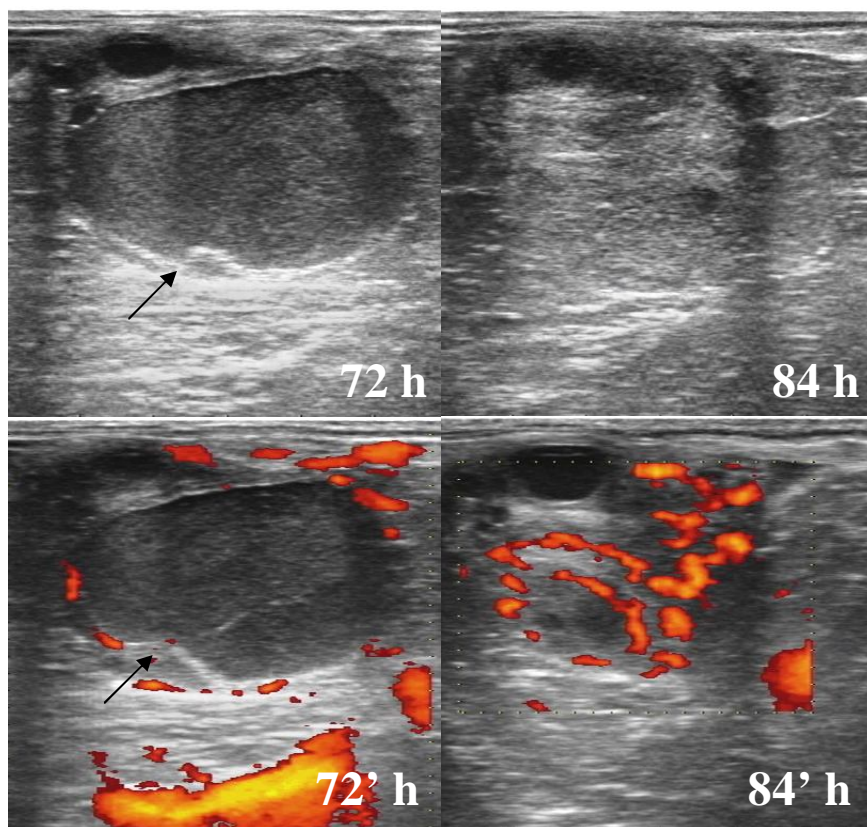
B-Mode and Colour-Doppler sonograms of a mare from LUF CLO 33 group. The mare was treated with 1.7 mg/kg flunixin-meglumine i.v. every 12 h from 0 to 36 h after hCG (0 h) and 250 μ g cloprostenol i.v. at 33, 35 and 36 h after hCG. The luteinized unruptured follicle (LUF) showed signs of follicular haemorrhage by 48 h. The LUF contents score increased gradually thereafter until 72 h. Between 72 and 84 h, the LUF collapsed. Note the disruption in the follicular wall integrity at the ventral left part of the LUF (black arrow: 72 h and 72' h). The degree of vascularisation of the follicular wall is indicated by the yellow-red colour intensity in Doppler sonograms before (72' h) and after (84' h) LUF collapse.
